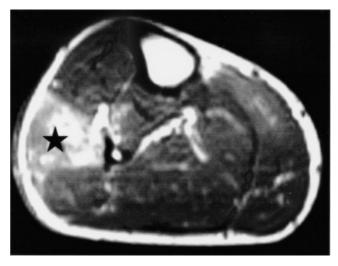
T₁-weighted axial gadolinium-enhanced MRI of the right calf, showing focal myositis (star) of peroneal muscles (increased signal intensity).
